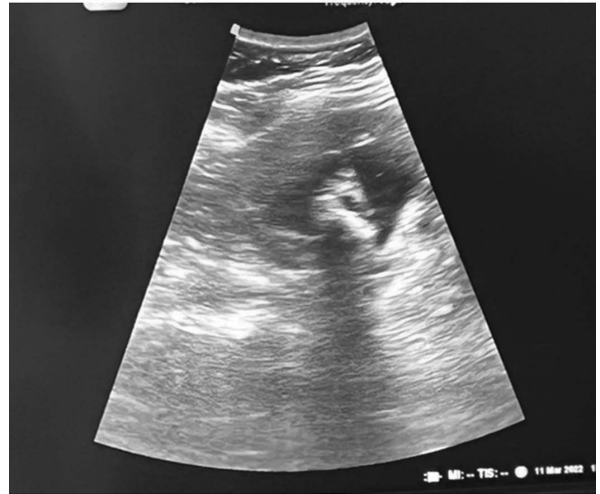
Kidney and Urinary Bladder Ultrasound showing a hyperechoic structure representing the staghorn calculi.
